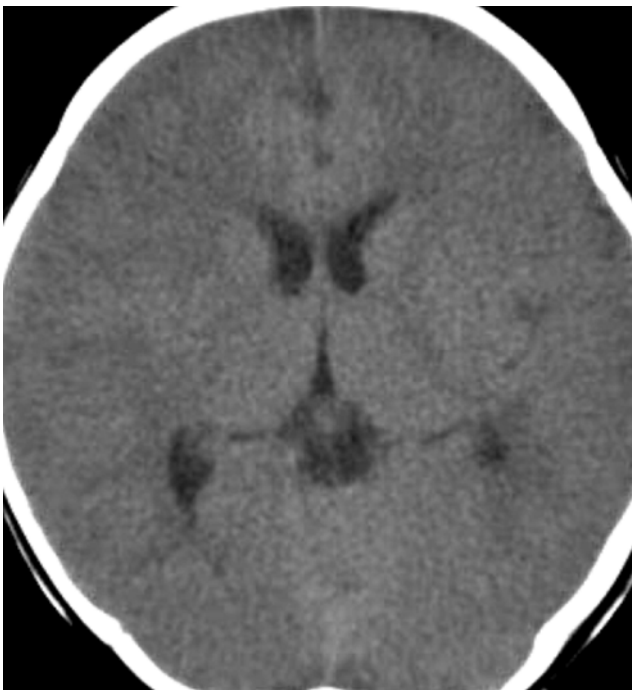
Initial brain CT images show ill-defined low-density lesions in the cerebral cortex and subcortical regions and effacement of brain sulci.
